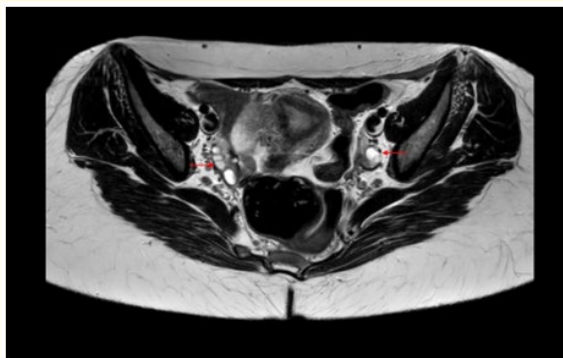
Pelvic MRI, coronal T2 sequence, showing both the right and left ovaries (arrows).
